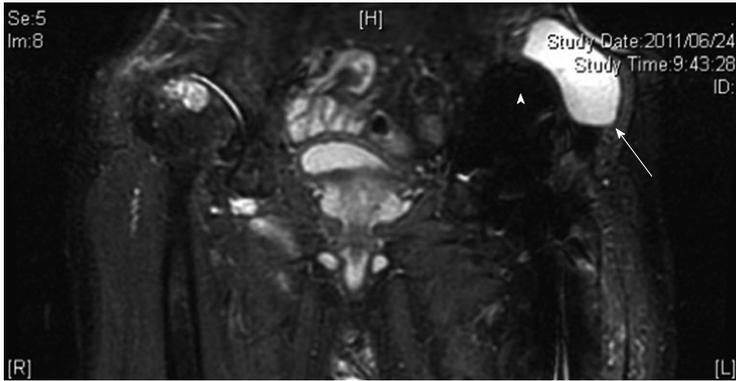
A 76-year-old male with a pseudotumor following cemented total hip arthroplasty, which was implanted 18 years earlier. Coronal short tau inversion recovery magnetic resonance image shows a cystic lesion (arrow) adjacent to the acetabular component (arrowhead).
